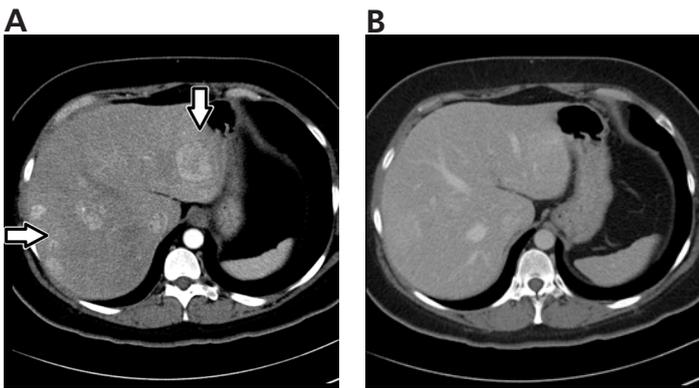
Biphasic CT scan showing typical dynamic phase imaging of an FNH. Arterial phase image (1A) demonstrates early arterial enhancement with portal phase image (1B) demonstrating portal venous washout.
